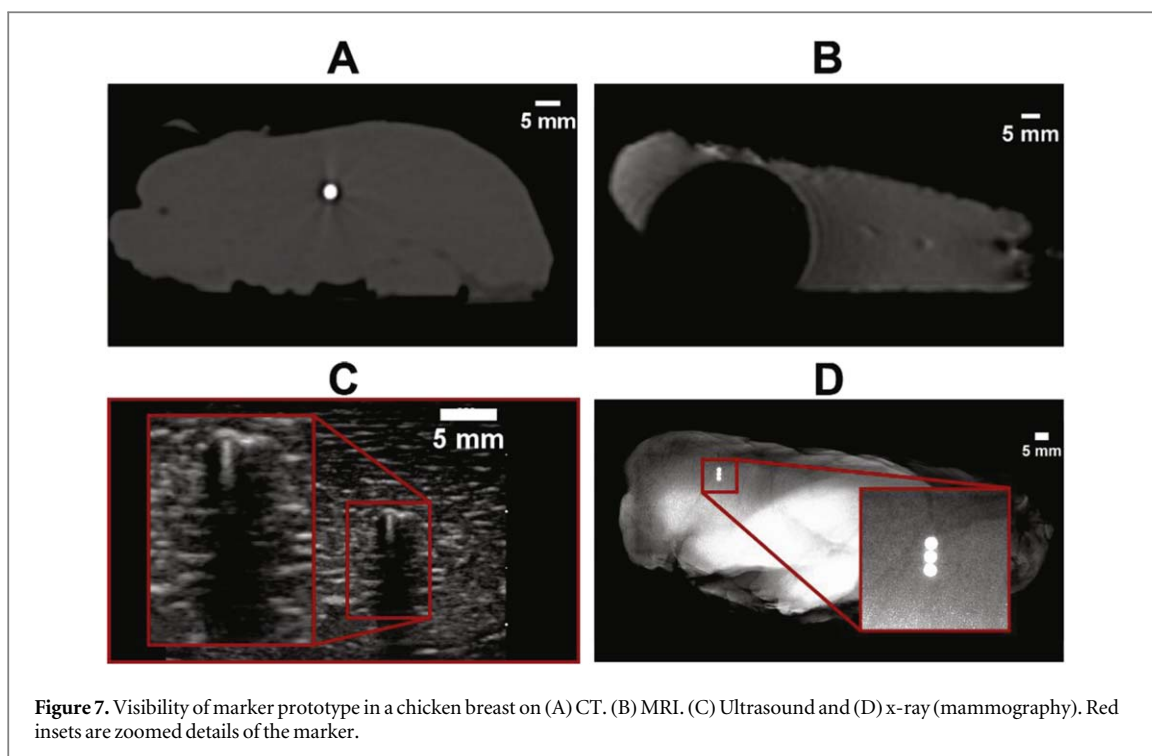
Visibility of marker prototype in a chicken breast on (A) CT, (B) MRI, (C) Ultrasound and (D) x-ray (mammography). Red insets are zoomed details of the marker.
